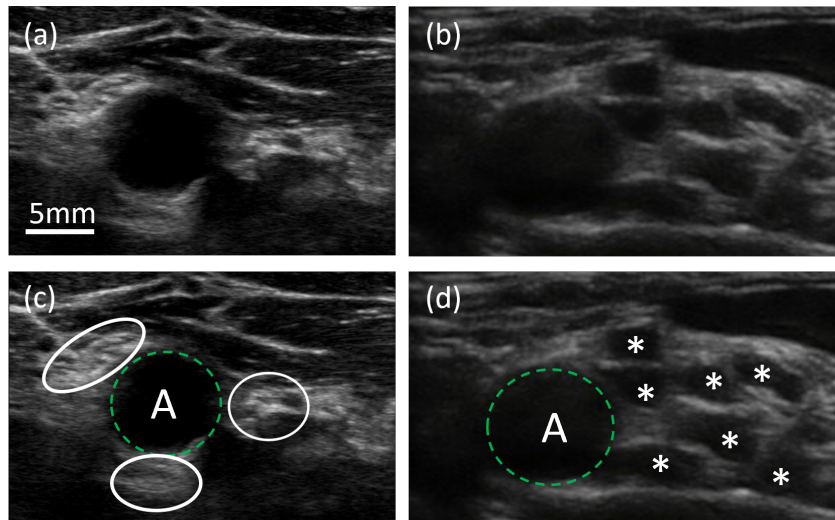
Ultrasound imaging of human nerves in vivo (a) example of hyperechoic nerves (b) example of hypoechoic nerves (c) marked up version of image in *a* to highlight artery (A) surrounded by the lateral, median, and posterior cord, which are hyperechoic nerve bundles (white ellipses) (d) marked up version of image in *b* to show artery (A) surrounded by brachial plexus divisions, which appear hypoechoic (*)
